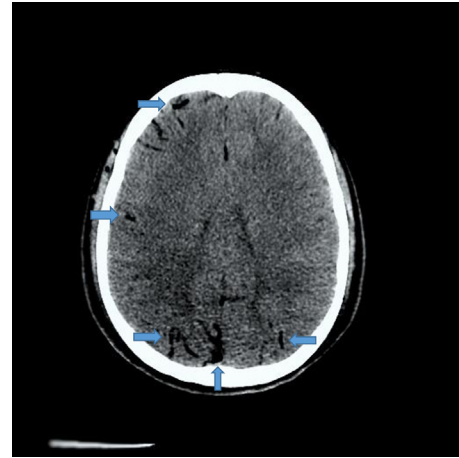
Brain CT demonstrating pneumocephalus.
